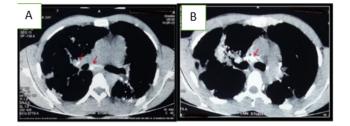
A & B: Mediastinal window of HRCT chest showing irregular pleural thickening with calcification, calcified right hilar and mediastinal lymphadenopathy
